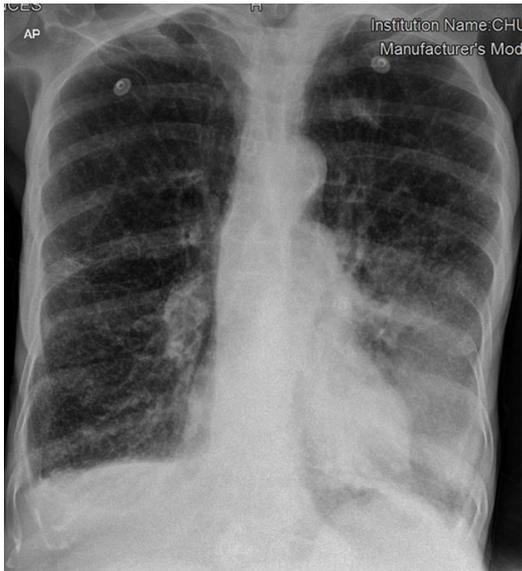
A front chest x-ray showing partial radiological resolution of alveolar consolidation of left lower lobar
